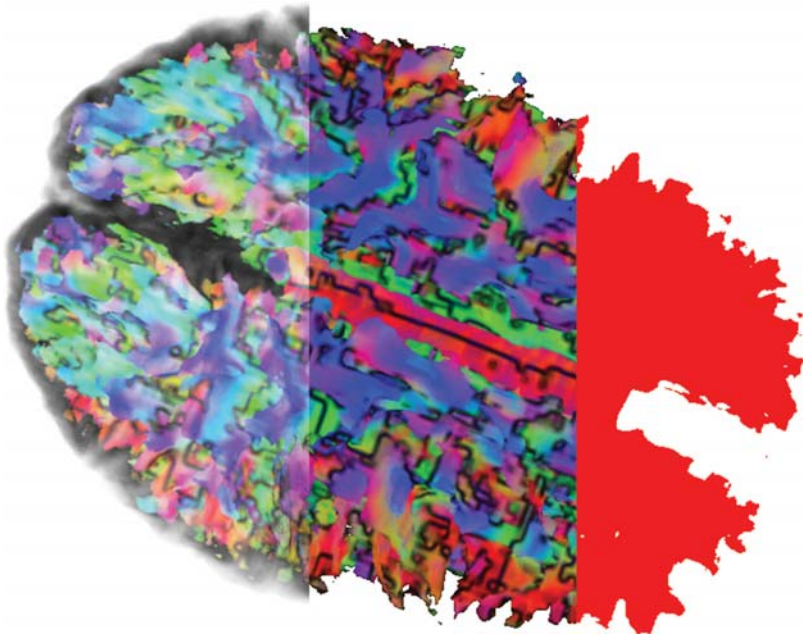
Three components of the compositing step – from right to left: importance mask, directional-colored DTI data, final compositing with MRI data
